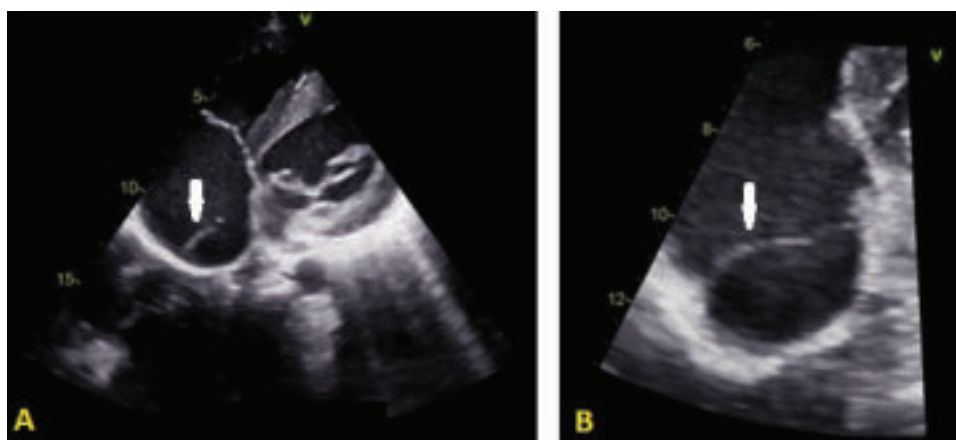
2D echocardiography showing Chiari network in right atrium in off-axis view (Panel A), and zoomed up view (Panel B), marked by white arrows.
